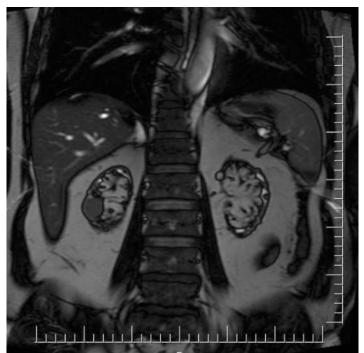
MRI study: 24.4 mm x 23.8 mm nodular solid mass lesion located laterally in the upper pole of right native kidney
